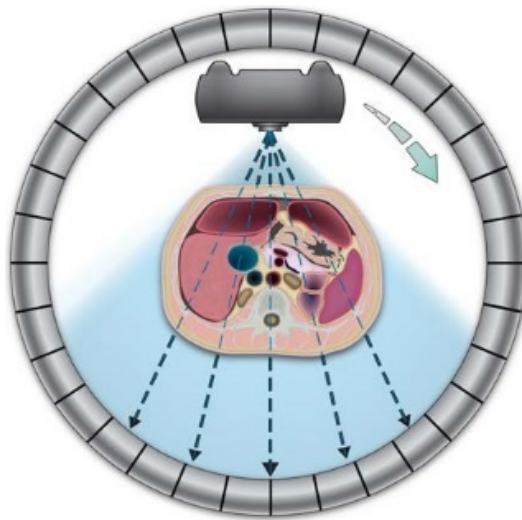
Fourth generation CT scanner.
